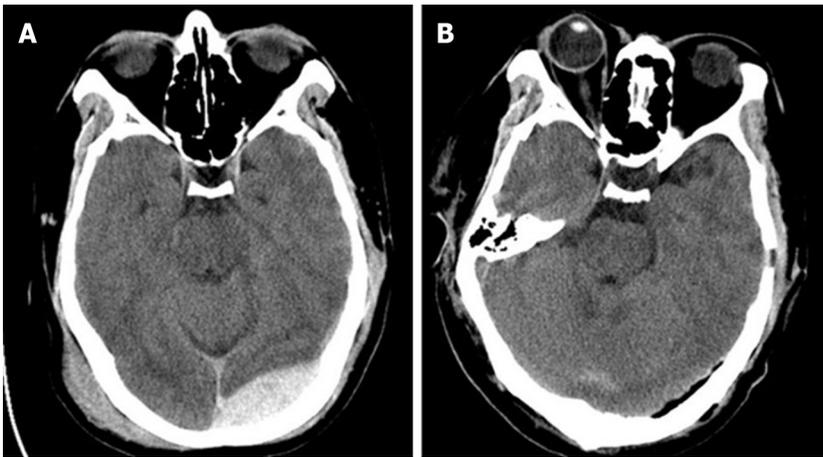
A pre- and postoperative computed tomography scan of a 29-year-old man after a traffic accident. A: The preoperative computed tomography (CT) scan showed the left supra- and infratentorial acute epidural hematoma (SIEDH) across the transverse sinus and the local occipital scalp hematoma; B: 24 h after surgery, the head CT showed that the SIEDH was completely cleared and the bone flap was perfectly fixed *in situ*.
